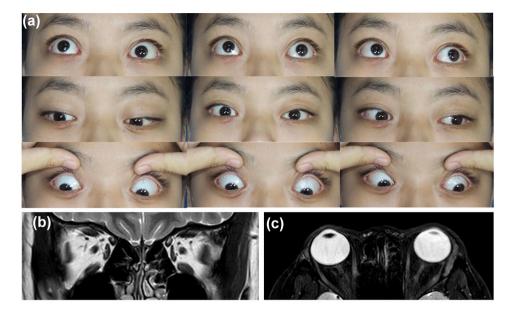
Nine-directional ocular photographs and orbital MRI after RTX treatment and orbital decompression surgery. (a) The nine-directional ocular photographs revealed significant ocular improvement after the surgery. (b, c) Orbital MRI demonstrated improvement of orbital inflammation on coronal (b) and transverse (c) T2-weighted imaging.
